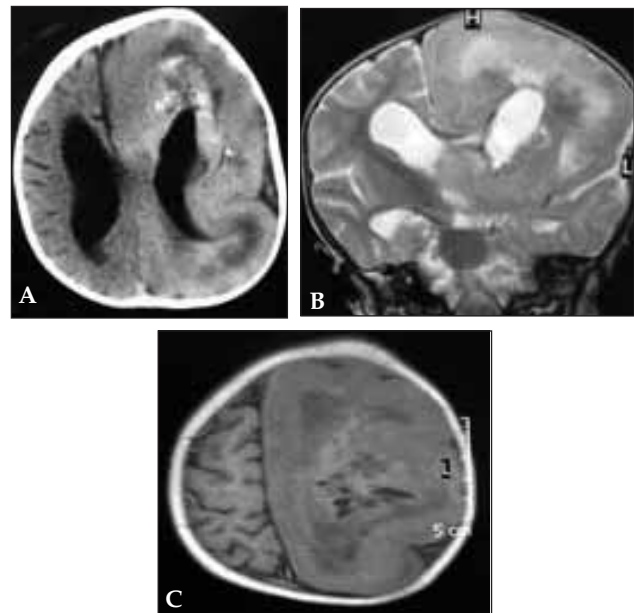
1B and 1C: MRI shows frontotemporal mass extending to the calvarium, congenital agenesis of corpus callosum, and pachygyria.
